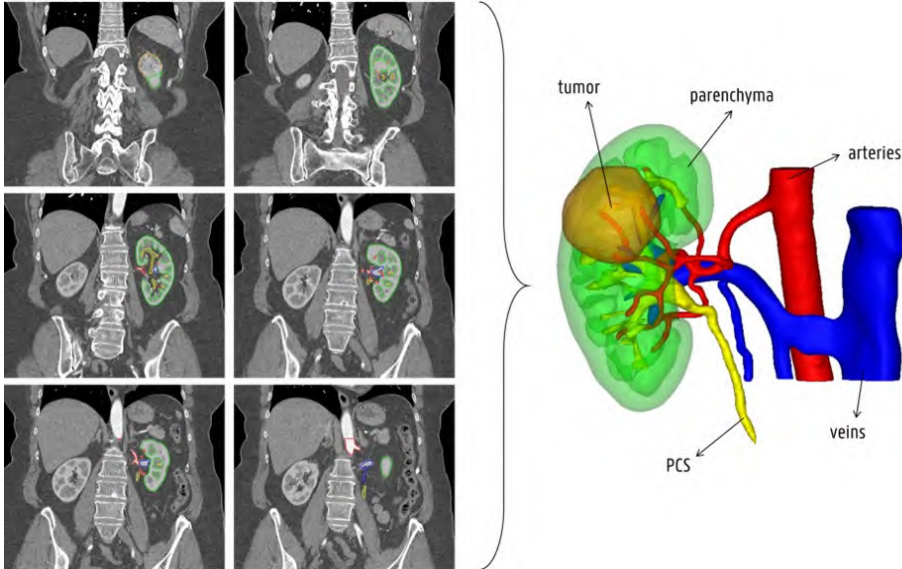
All structures (tumor, parenchyma, cysts (if any), arteries, veins and pelvi-calyceal system) are segmented in Mimics (Materialise, Belgium) using the four different phases of the CT-scan. Subsequently, all segmentations are aligned on the arterial phase (left) and 3D reconstructed (right). Identical colors are used on both panels.
